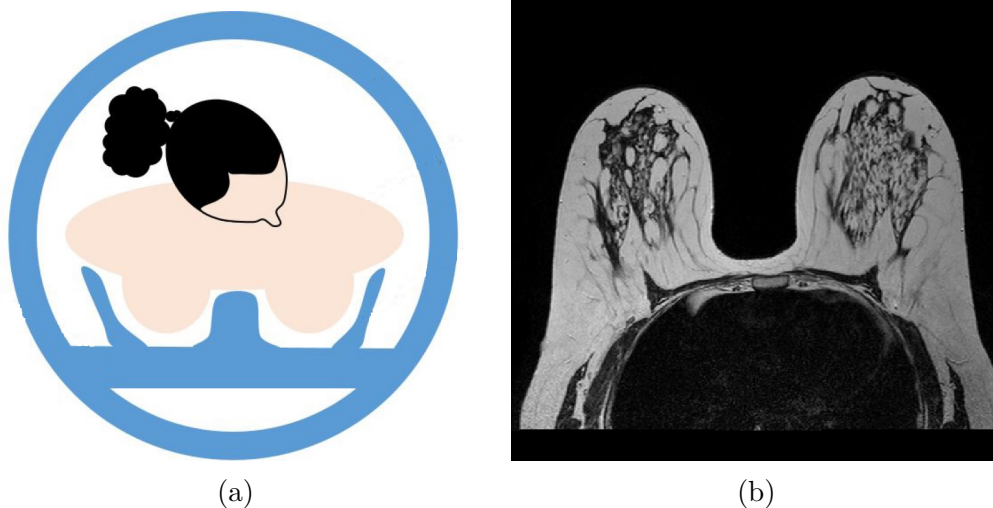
(a) Prone position during MRI [131]; (b) pre-contrast (axial slice) MRI slice
